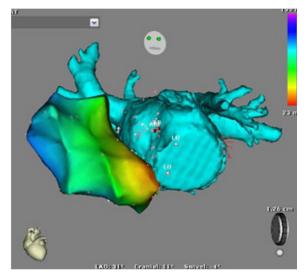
Computed tomography of the left atrium and electroanatomical reconstruction of the right atrium with activation of the right atrium during tachycardia.
